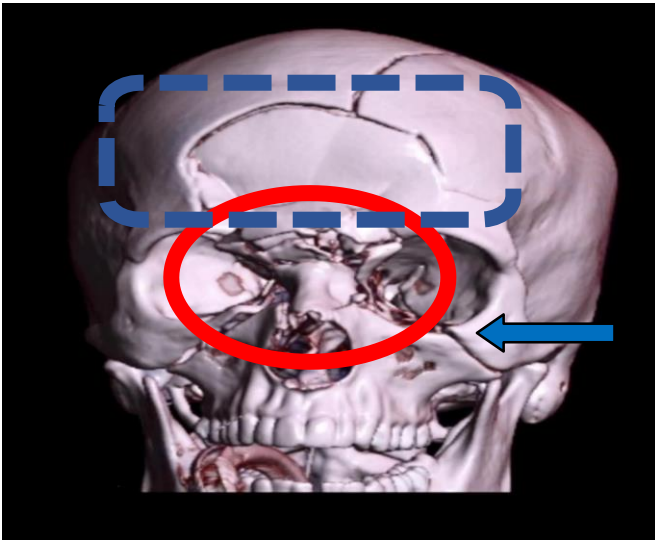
CT scan demonstrating depressed frontal bone fracture with frontal sinus involvement.
